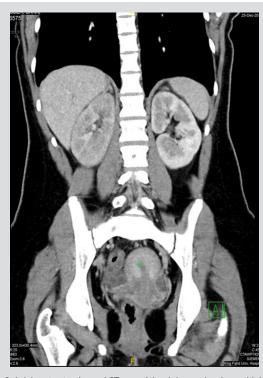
Axial contrast-enhanced CT scan of the abdomen showing multiple areas of decreased enhancement (low attenuation) in the right kidney, and normal renal arteries and veins. This is suggestive of acute pyelonephritisthrombosis
